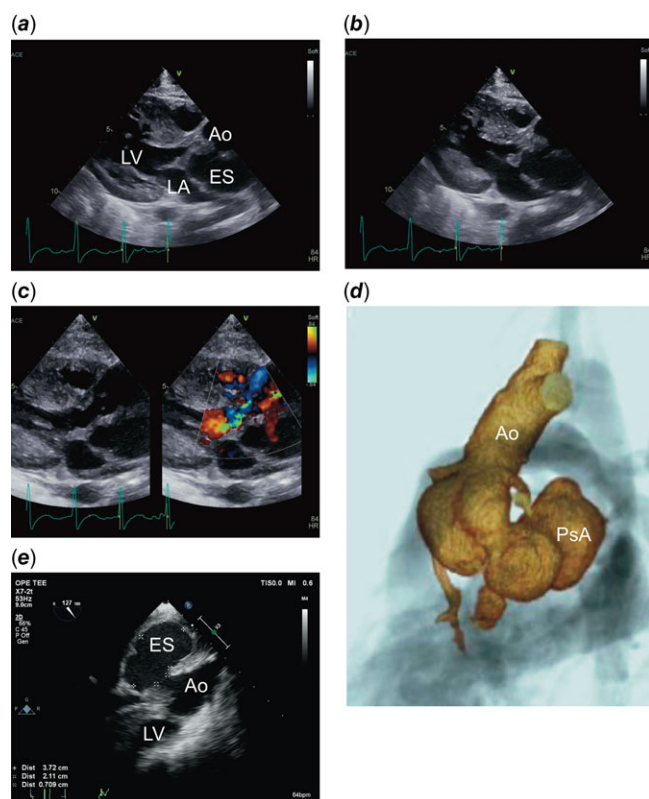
(a) Transthoracic echocardiogram in the parasternal long-axis view (systolic phase). The figure shows an echolucent space (43.5×21.5 mm). (b) Transthoracic echocardiogram in the parasternal long-axis view (diastolic phase). The figure shows a thickened posterior aortic valve leaflet during the diastolic phase. Below the leaflet, there is an echolucent space between the aorta and the left atrium. (c) Transthoracic echocardiogram with colour flow in the parasternal long-axis view. The figure shows an abnormal flow between the aorta and the echolucent space. (d) Cardiac CT angiogram (3D reconstruction). The figure shows that a pseudoaneurysm (44.5×36.5×28.5 mm) expands below the sinus of Valsalva. (e) Transesophageal echocardiogram. The figure shows an ostium (7.0 mm) between the aorta and echolucent space. Ao=aorta; ES=echolucent space; LA=left atrium; LV=left ventricle; PsA=pseudoaneurysm.
